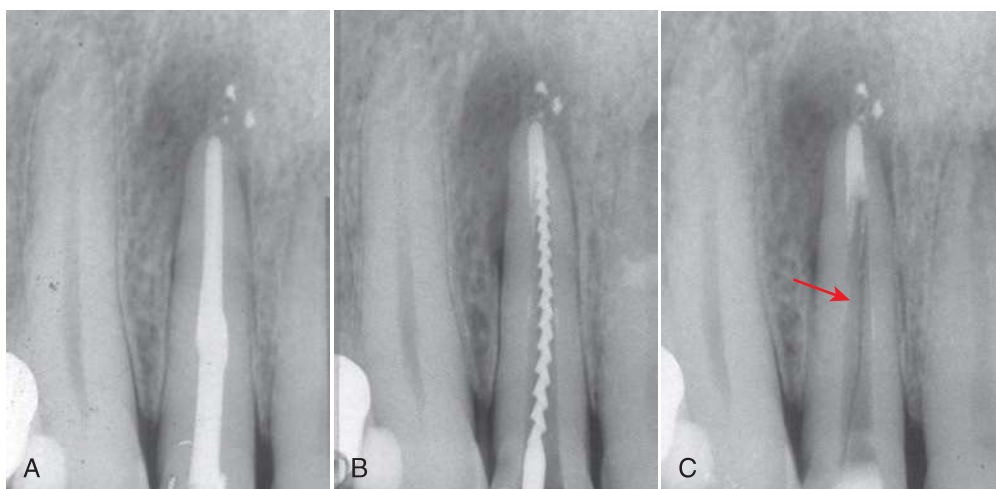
Radiography of an empty canal: a clinical case. The right maxillary lateral incisor underwent a root canal treatment a few years ago. The patient complained about occasional pain on the palatal side. The tooth was sensitive to percussion and palpation on the palatal side. Radiography revealed a periapical radiolucency (A). An isolated, deep, and narrow pocket was found on the palatal side of the root. Both the patient and the referring dentist were reluctant to extract the tooth, assuming that the pocket could potentially be a sinus tract, and decided on retreatment. A radiograph taken with a file during the process (B) could have missed essential information that was obscured by the file, which was an evident VRF (C).
